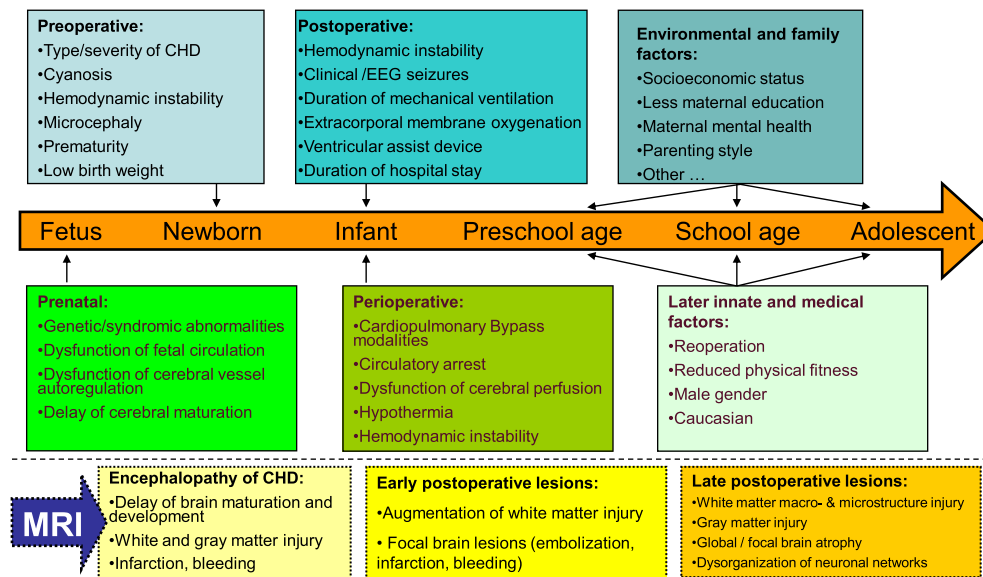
Factors-influencing neurodevelopmental outcomes in relation to brain magnetic resonance imaging.
